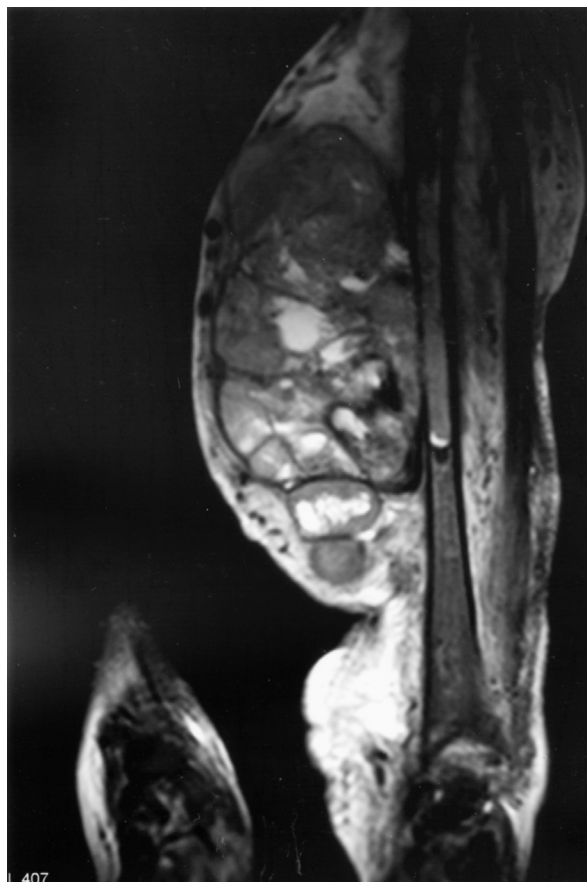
T-1 weighted magnetic resonance image with contrast shows multiple lobular plexiform soft tissue tumors with tibial destruction.
